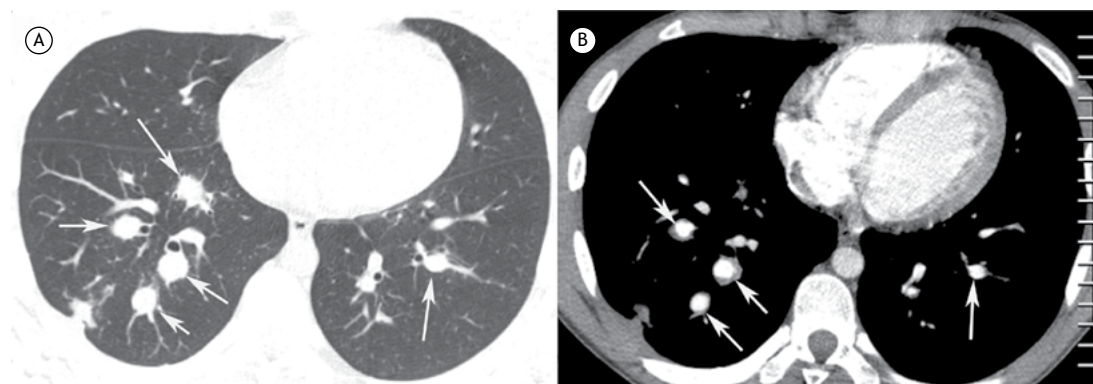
In A, unenhanced CT scan of the chest (lung window) showing multiple nodules (arrows) in the lower lobes, adjacent to the bronchi. In B, iodinated contrast-enhanced CT image (lung window) showing contrast opacification of the nodules (arrows), characterizing pulmonary artery aneurysms.
